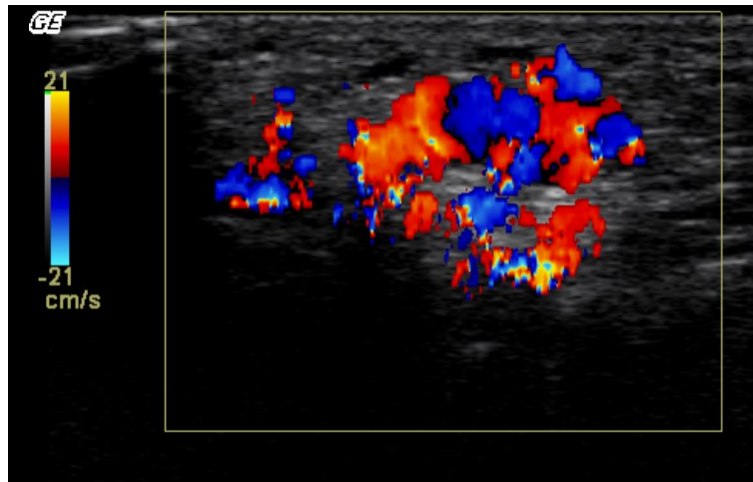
Hypotenar of five-years old child: hypervascular mass – colour Doppler image showing high velocity flow with red and blue colours in arterial and venous convolutes
